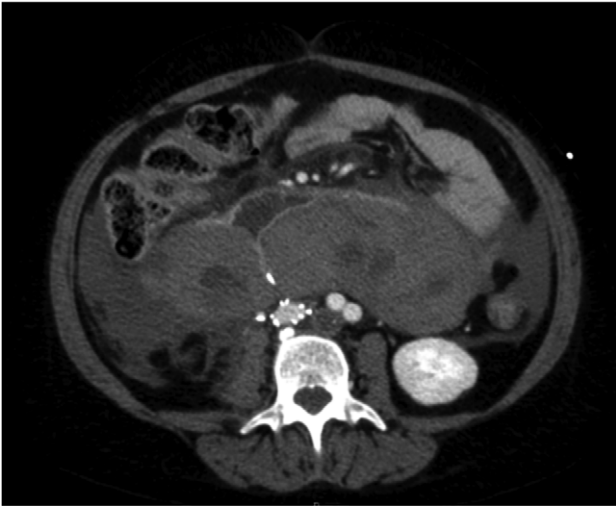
A venous phase abdominal CT demonstrating the end of the IVC filter strut penetrating the wall of the third part of the duodenum.
